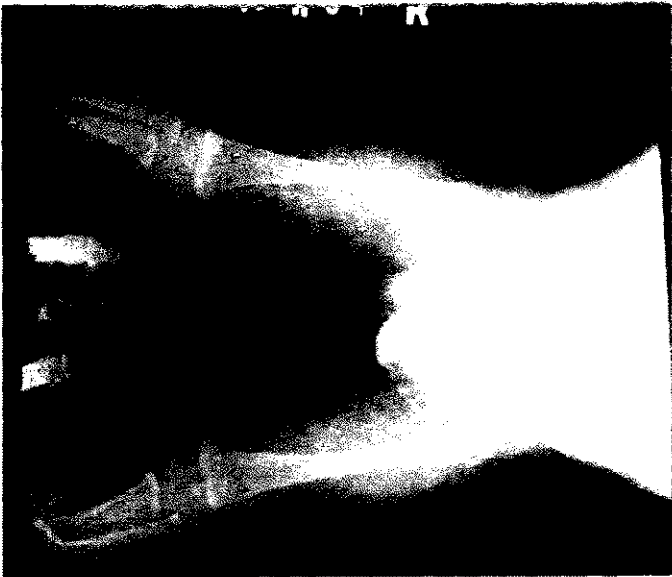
Figure II The x-rays of legs show bilateral partial longitudinal deficiency of both tibia.
